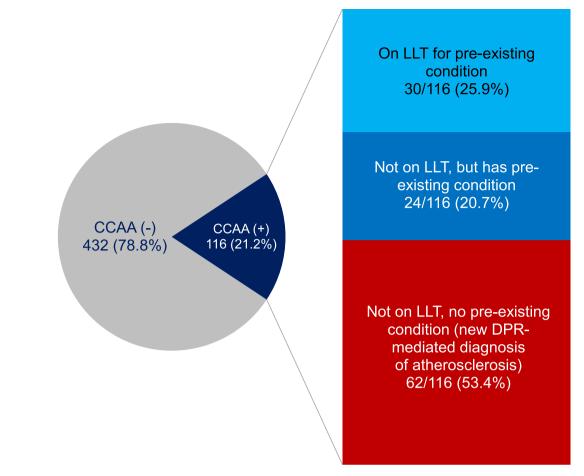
Prevalence of calcified carotid artery atheroma and associated use of lipid lowering therapy. Over half of patients with calcified carotid artery atheroma on dental panoramic radiographs represent a new diagnosis of atherosclerosis. CCAA-positive patients were stratified by those taking LLT and those with pre-existing indications for treatment with LLT. CCAA, calcified carotid artery atheroma; DPR, dental panoramic radiograph; LLT, lipid-lowering therapy.
